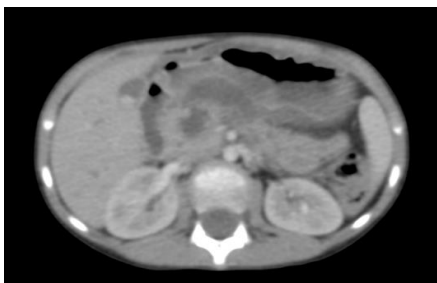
CT scan of a 6-year-old female who had bicycle accident shows hypodense area in pancreatic head region (representing laceration) consistent with grade IV injury. Peripancreatic fluid in lesser sac is also noted.
